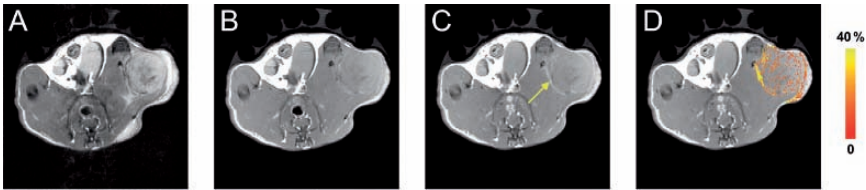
Molecular MR imaging of ongoing angiogenesis as detected by RGD-conjugated QD-micelles. T_2 -weighted image (A), collected before the contrast agent was injected, shows the contour of the tumor on the flank. T_1 -weighted images (B–D) measured before (B) and 45 minutes after (C, D) the injection of the RGD-pQDs. The arrow in (C) indicates a bright region at the periphery of the tumor. In (D) pixels in the tumor with signal enhancement of at least three times, the noise levels are color coded according to the pseudo-color scale on the right.
